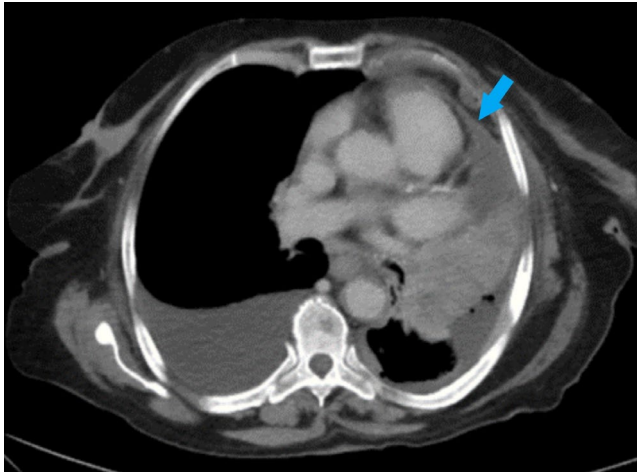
Axial chest CT shows pericardial wall thickening (blue arrow)
